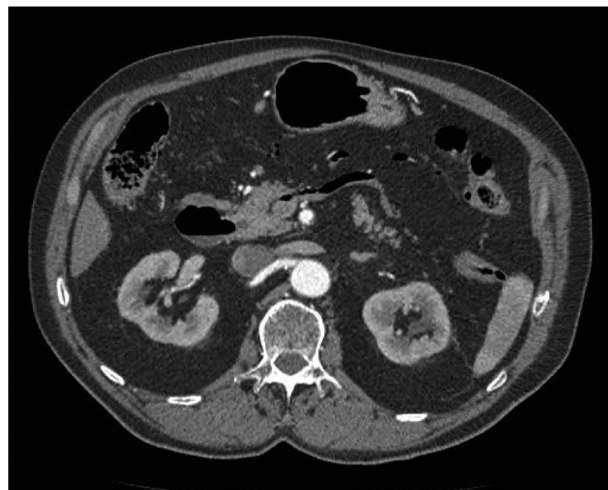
Abdominal-pelvic CT scan with intravenous contrast: extensive air level is observed at the splenic vein.
